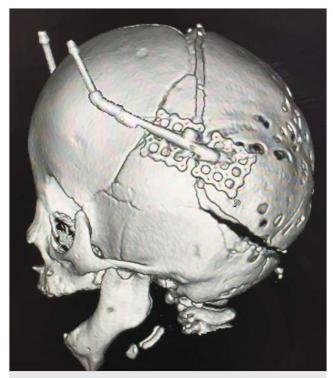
A lateral skull radiograph demonstrating the completed osteotomies and placement of the bilateral internal distractors.
